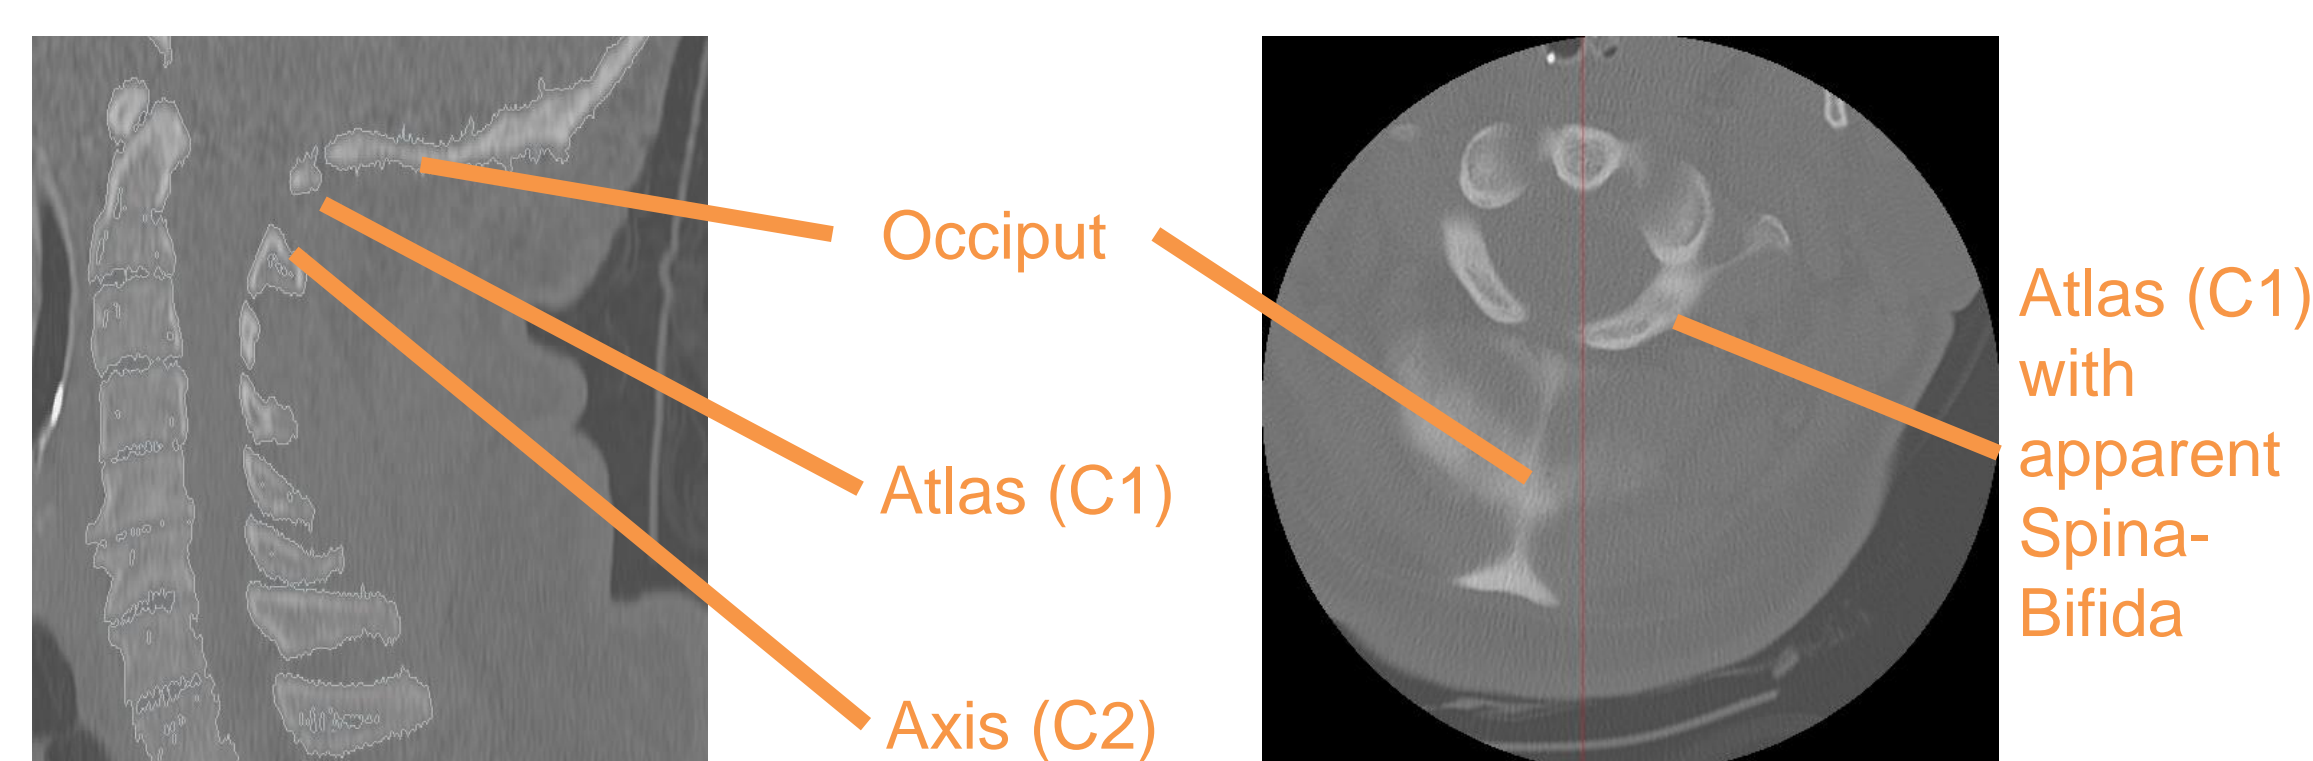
Sagittal view of cervical spine CT
